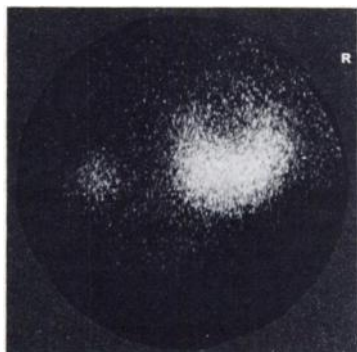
After 11 days of ACTH, preoperative posterior adrenal scintigram at 6 days after 19-Iodocholesterol(I-131). Here is "scintigraphic reactivation" of normal left adrenal.
